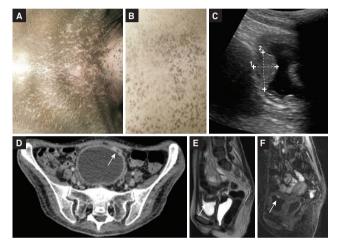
Malignant acanthosis nigricans and paraneoplastic screening. (A,B) Symmetric hyperpigmented cutaneous lesions without mucosal involvement. Paraneoplastic imaging screening disclosing an intramural intravesical lesion (white arrow) in ultrasonography study (C), abdominal and pelvic CT (D) and T2-weighted (E) and post-gadolinium STIR (F) sequences in MR imaging of the abdomen and pelvis.
